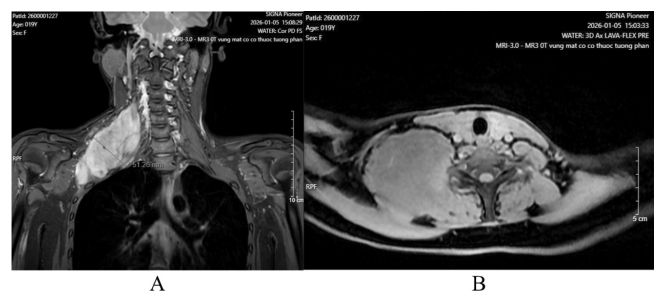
Preoperative magnetic resonance imaging of the cervical–thoracic region (A: sagittal view, B: axial view)
